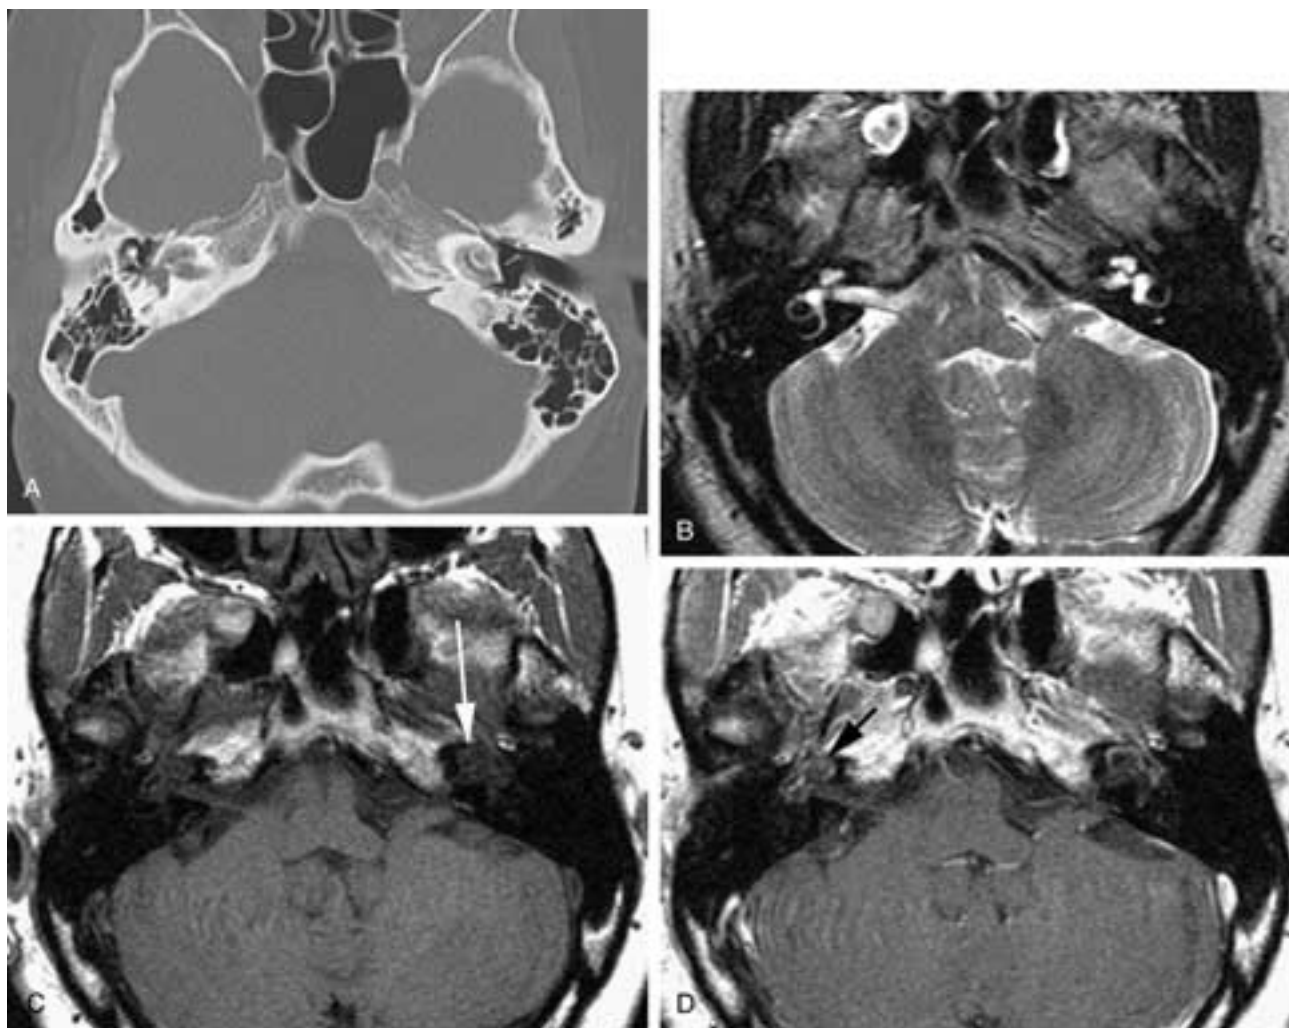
Cochlear otosclerosis, CT and MR scans. A, Axial image shows the demineralization around the cochlea on either side. This gives the appearance of the double ring or fourth turn of the cochlea. B, MR T2-weighted image shows the lumen of the cochlea but only a very faint hint of demineralization on the left side. C, Axial T1-weighted image shows the indistinctness of the outline of the labyrinth because of the demineralized bone (arrow) surrounding the lumen of the cochlea. D, Enhancement of the demineralized bone (arrow). (From Sakai O, Curtin HD, Fujita A, et al. Otosclerosis: CT and MR finding. *Am J Otolaryngol* 2000;21(2):116-118.)
